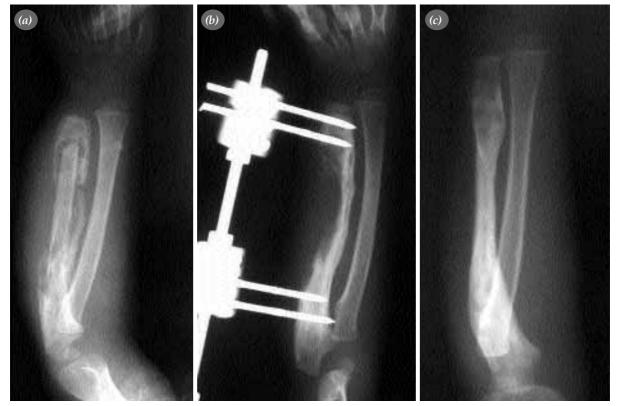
(a) A-P x-ray of the case with OM after ulnar fracture, showing the sequester and the involucrum formation around it. (b) Postoperative A-P forearm x-ray of the same case. Sequestrectomy was done and uniplanar external fixation was performed. (c) Shaft regeneration took place after three months.
